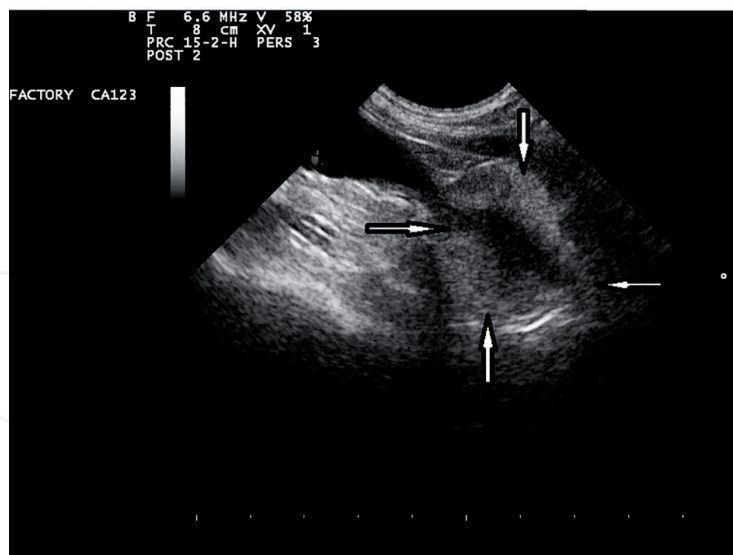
Sonography (B-mode) of the physiological prostate. Prostate gland of a healthy 5-year-old beagle, the white arrows mark the contour. The size was 3 × 2 cm (L × W), the structure of the gland is homogenous, the echogenicity is physiological, and the anechoic line in the middle is the urethra.
